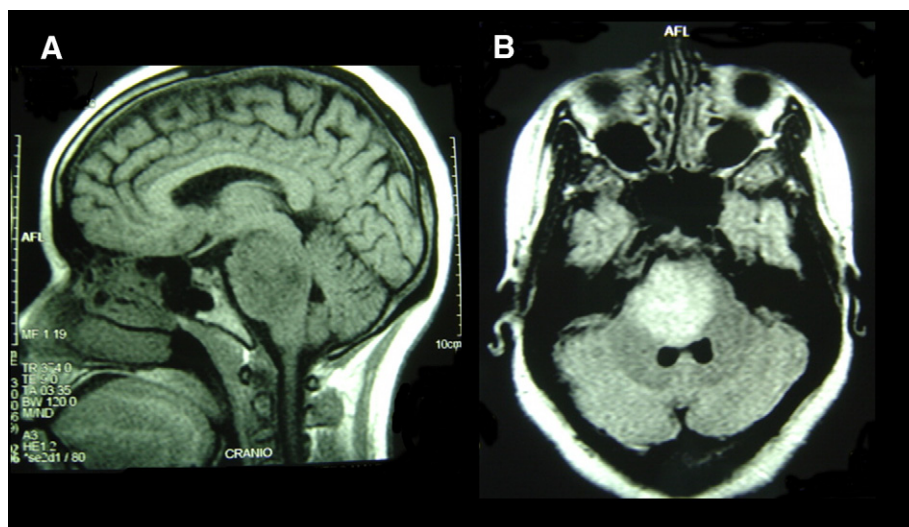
MRI of a 26-year-old patient with a diffuse infiltrative pontine glioma. (A) Sagittal T1– weighted. (B) Axial FLAIR image.
